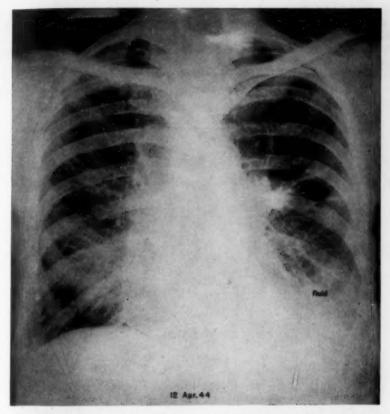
Case 2. X-ray of April 12, 1944, showing diffuse linear infiltration of both lungs with fluid in the left base.
